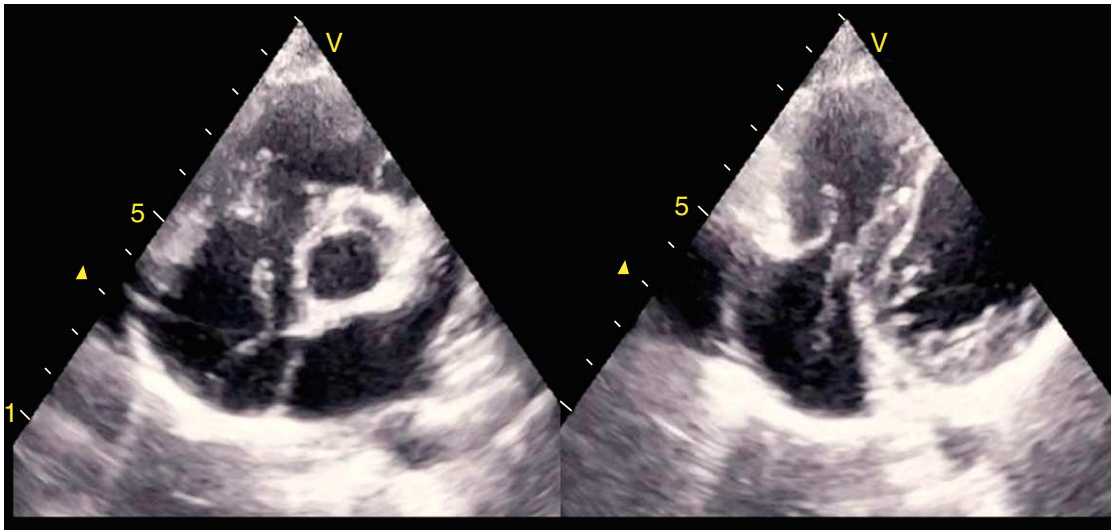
2D-echocardiogram image showing Chiari's network in right atrium moving towards tricuspid valve.
